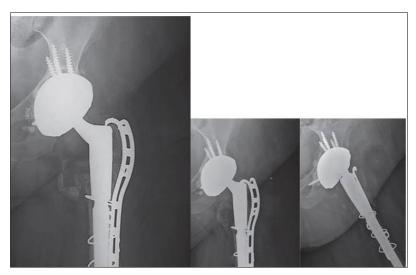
Anteroposterior (AP) radiograph before Intraprosthetic dislocation, and b) AP and lateral radiograph after a failed closed reduction that resulted in an Intraprosthetic dislocation^[5]
